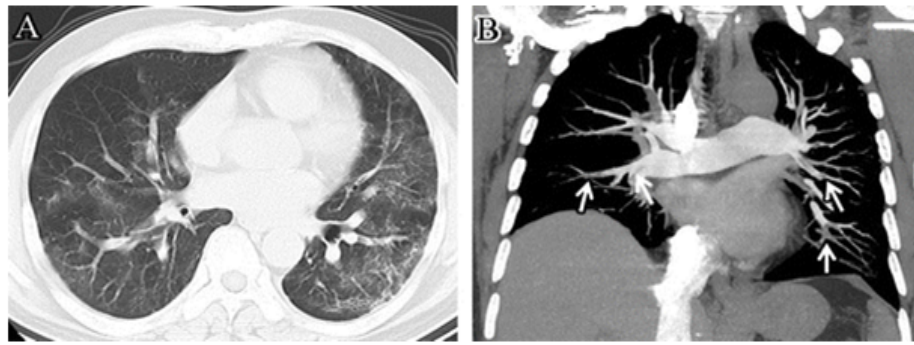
Patient of COVID-19 having Pneumonia with Age 57 year. (A) On Day 10 CT Showing Ground Glass Opacities at Periphery. (B) Angiography of Arteries at Lungs Showing Filling Defects [13].
